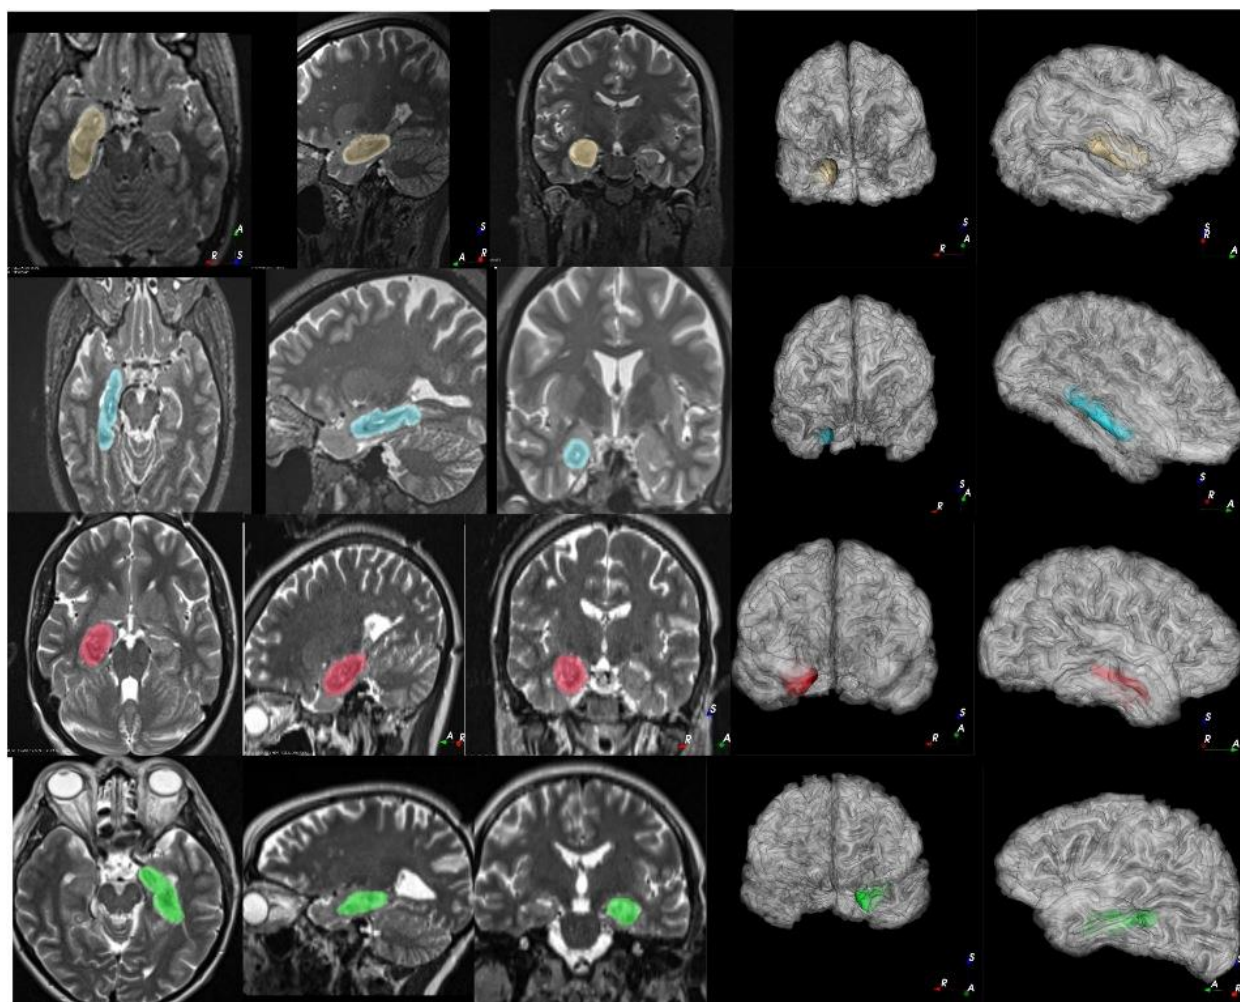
Ablation comparison of LITT and RFA. MTL-LITT MTS (Yellow), MTL-RFA MTS (Blue), MTL-LITT MRI negative (Red), and MTL-RFA MRI negative (Green).
